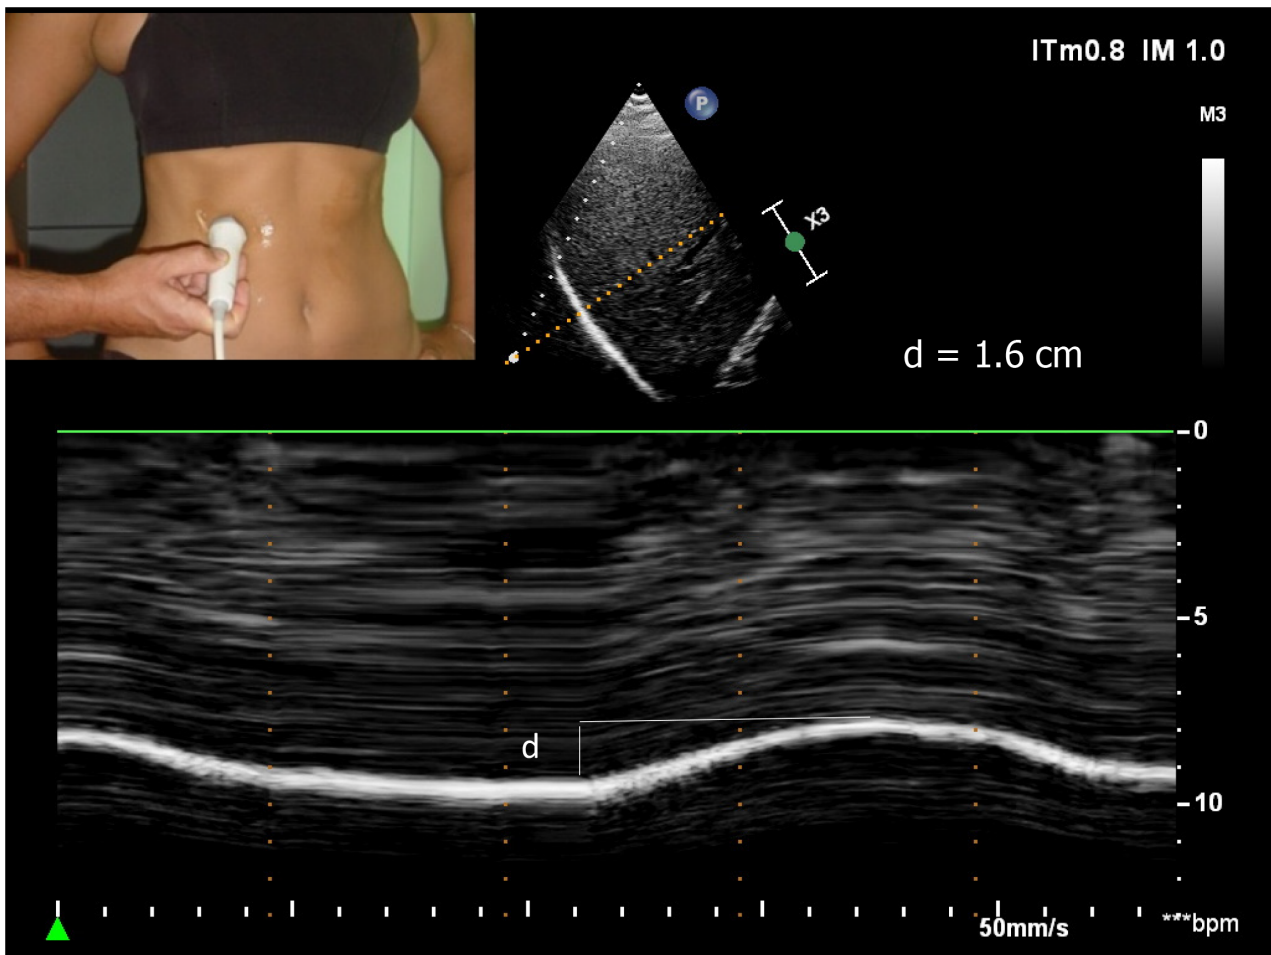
Diaphragmatic motion recorded by M-mode ultrasonography during quiet breathing d: Measurement of diaphragm excursion = 1.6 cm.
